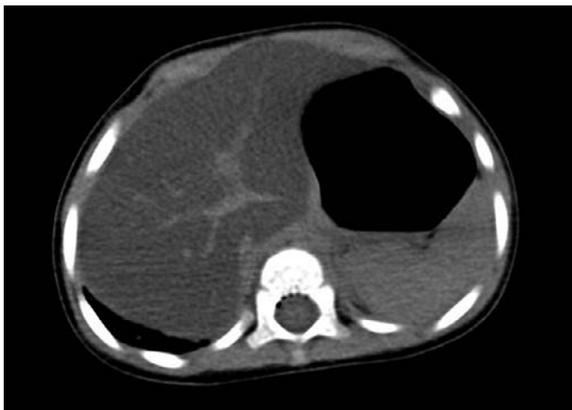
Postmortem computed tomography image of the abdomen. Postmortem computed tomography was performed at the hospital to which the deceased had been transferred. The image demonstrates low absorbance in the whole liver, suggesting severe fatty liver.
